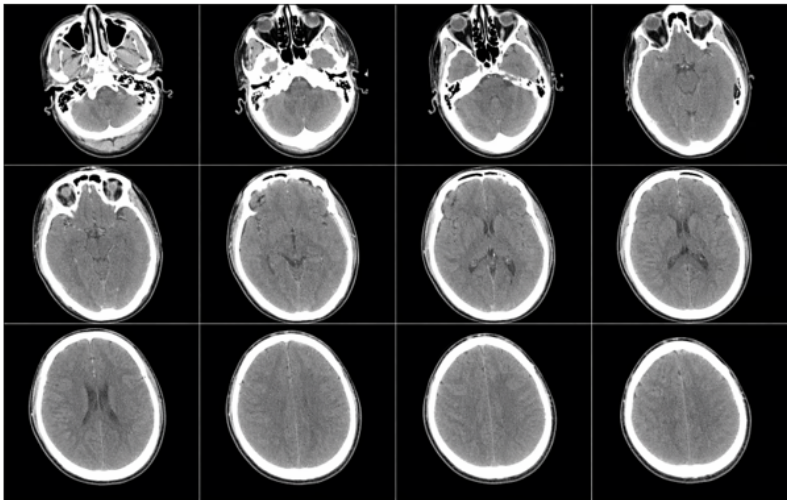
Follow-up brain CT (day 3): Multiple oedemato-haemorrhagic contusion foci and effacement of the cortical sulci indicating the onset of cerebral oedema.
